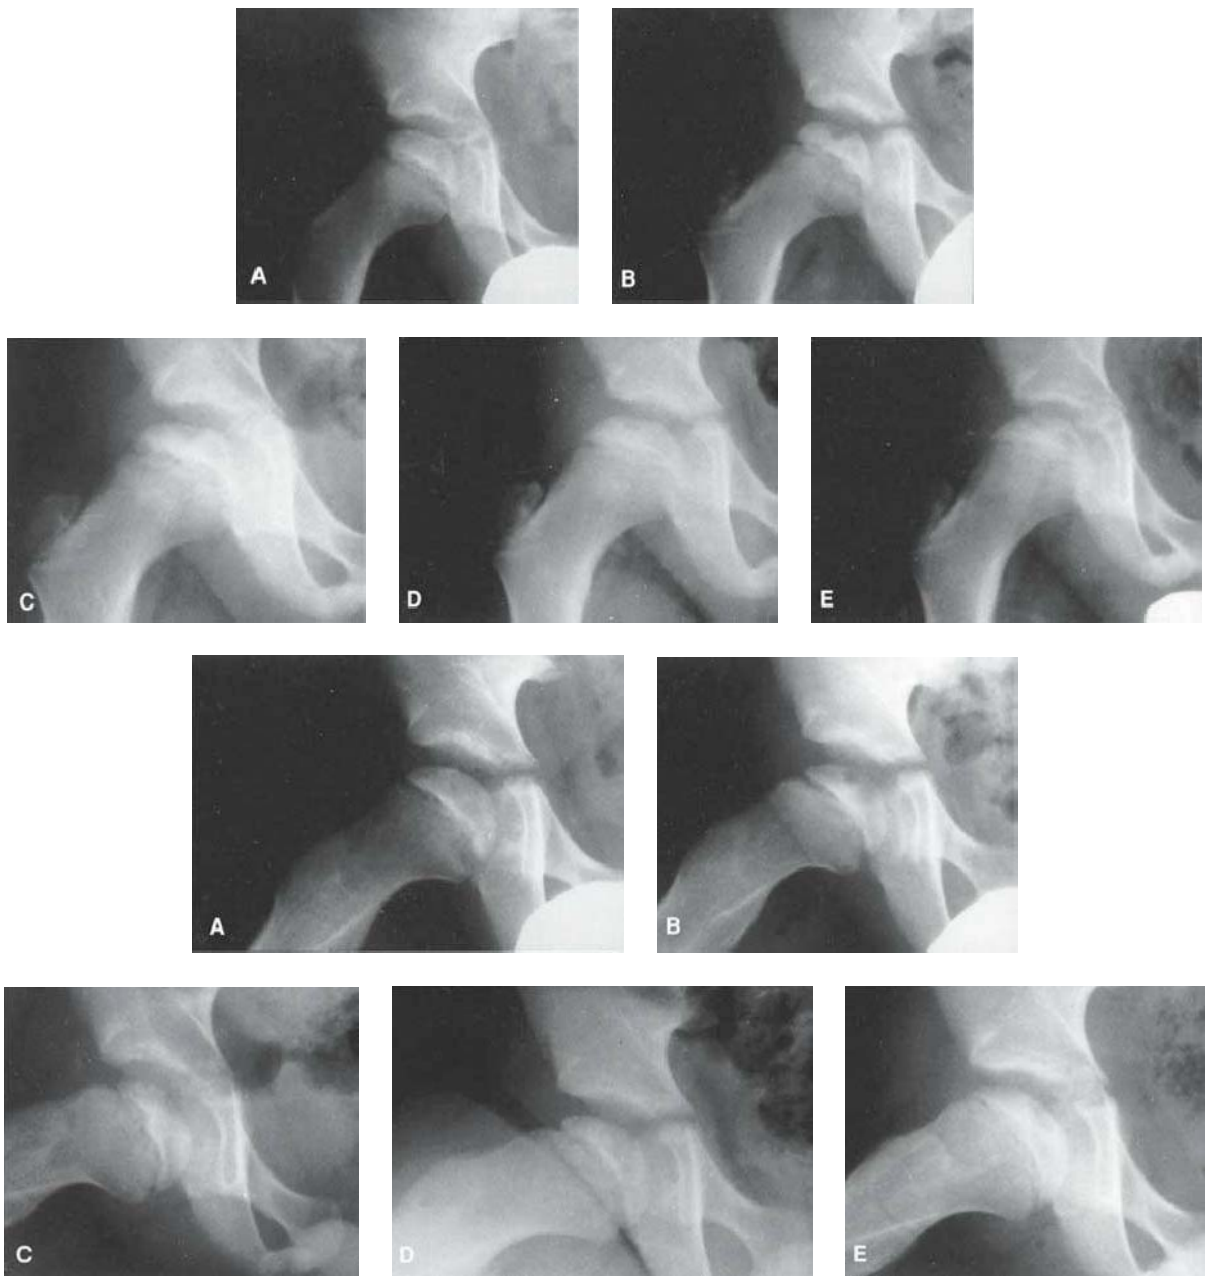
AP (top, A–E) and lateral (bottom, A–E) views of a 7-year-old boy who presented with hip pain and a limp. A: At presentation, the patient was in the initial radiographic stage of the disease; his prognosis was indeterminate. B: Six months after presentation, he had minimal loss of height of the lateral pillar and some radiolucency in that region, as well as significant bone resorption centrally. Note how the lateral pillar maintains its height throughout the course of the disease. One year (C), 18 months (D), and 3 years (E) after onset of disease. The patient had only mild symptoms on occasion and maintained good range of motion throughout the course of the disease. Only symptomatic treatment was provided.
